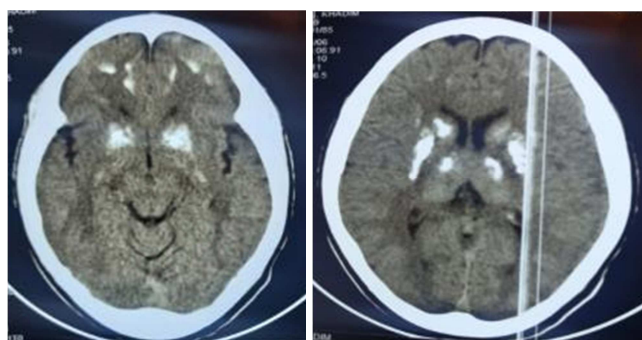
Brain CT: Calcification of the lenticular nuclei, caudate nuclei associated with parietal cortico-subcortical calcifications.
